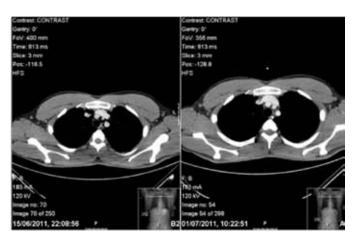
Computed tomography scan of chest with Gastrografin contrast; comparison of image on admission and image after resolution showing no pneumomediastinum.
